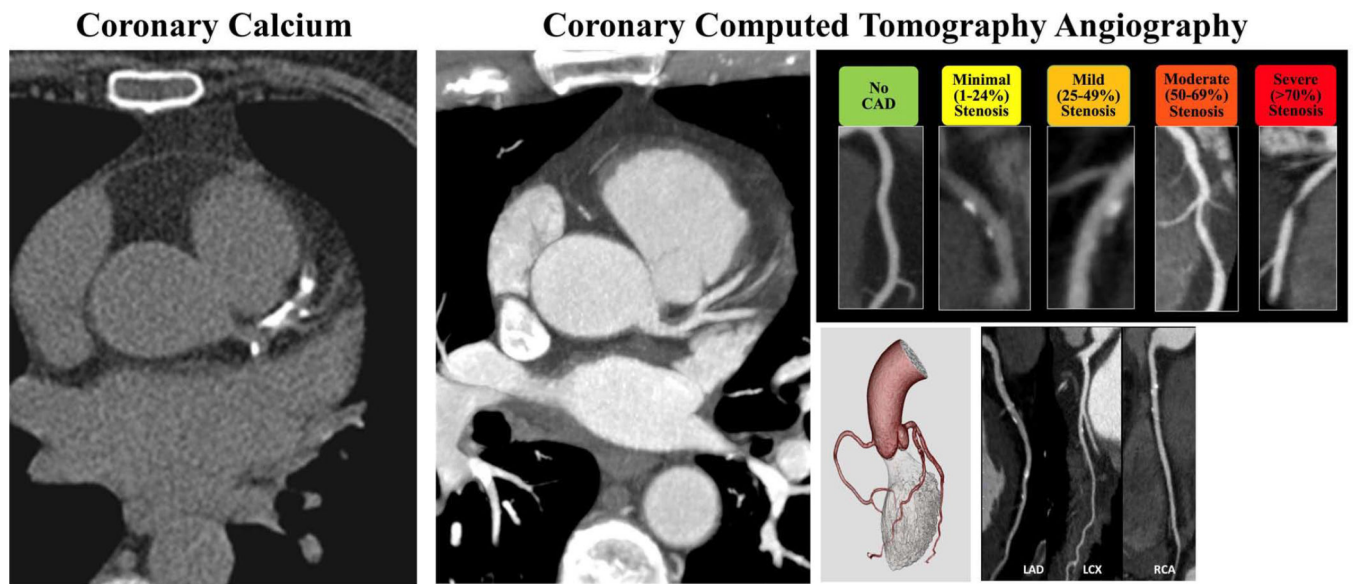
Coronary artery calcium scoring compared to Coronary Computed Tomography Angiography.
